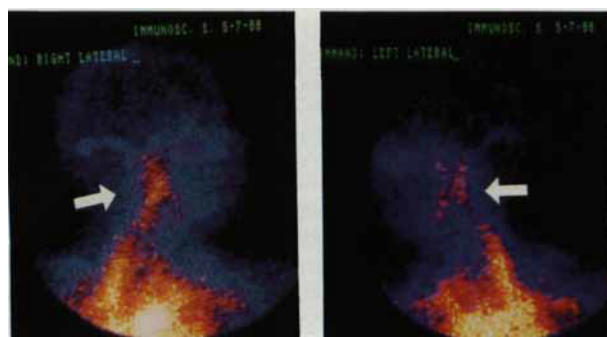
Lateral immunoscintigrams of a patient with an adenoid cystic carcinoma in the right parotid gland. a) Right side. b) Left side.
